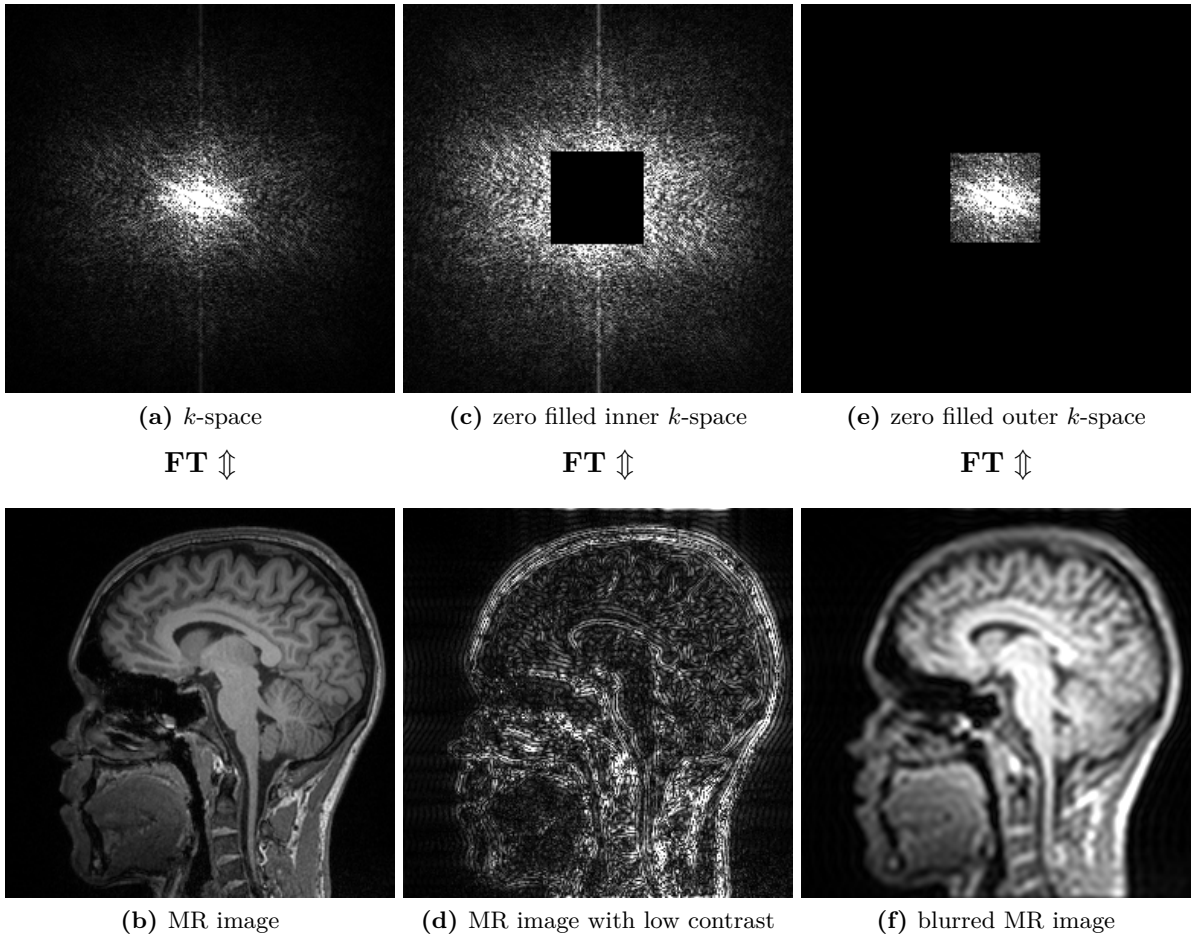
MR image reconstruction based on k -space data obtained through 3D MRI of a human head by means of inverse FT. The k -space center includes information about image brightness and contrast (low spatial frequencies), whilst the outer k -space data determine the spatial resolution of the object (high spatial frequencies).
